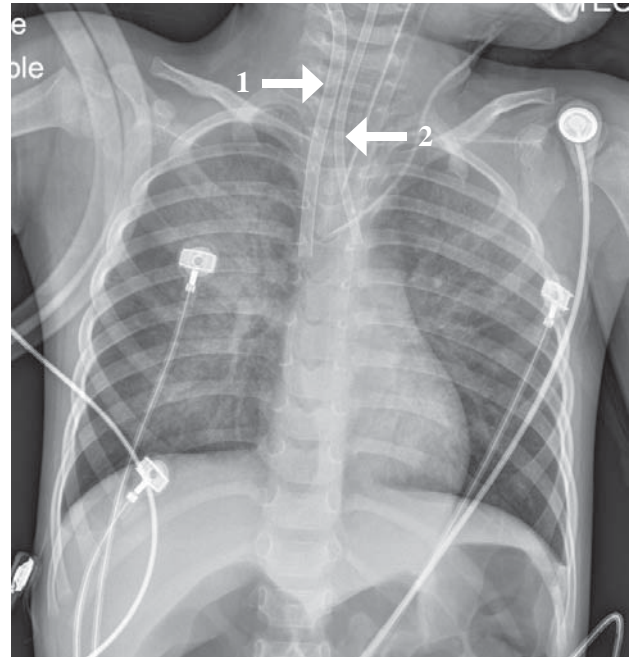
On January 23, 2013 at 21:41, a chest x-ray AP supine position and ECMO venous to arterial connection. The tip of catheter 1 is in SVC. The tip of catheter 2 is in the aortic arch. Progressive pulmonary edema developed.
